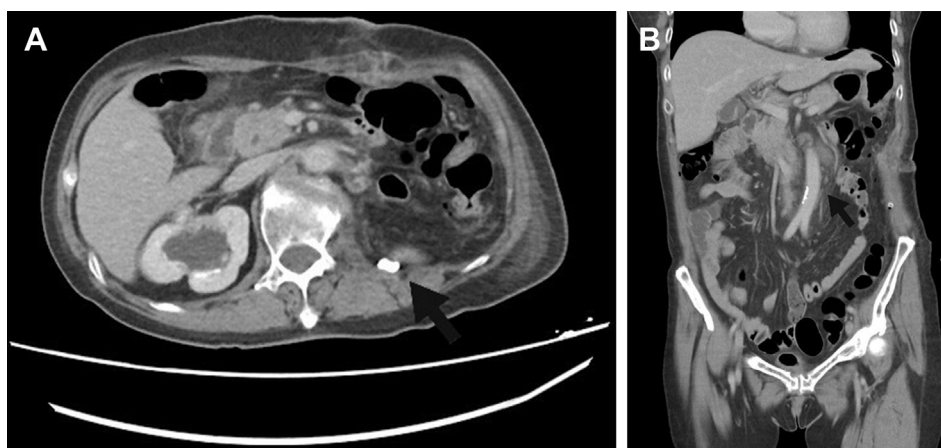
(A) Transverse view: abdominal computed tomography (CT) shows postoperative retroperitoneal drainage tube placement with minimal ascites. (B) Coronal view: abdominal CT shows small size para-aortic lymph node and no definite hollow organ injury is noted.
